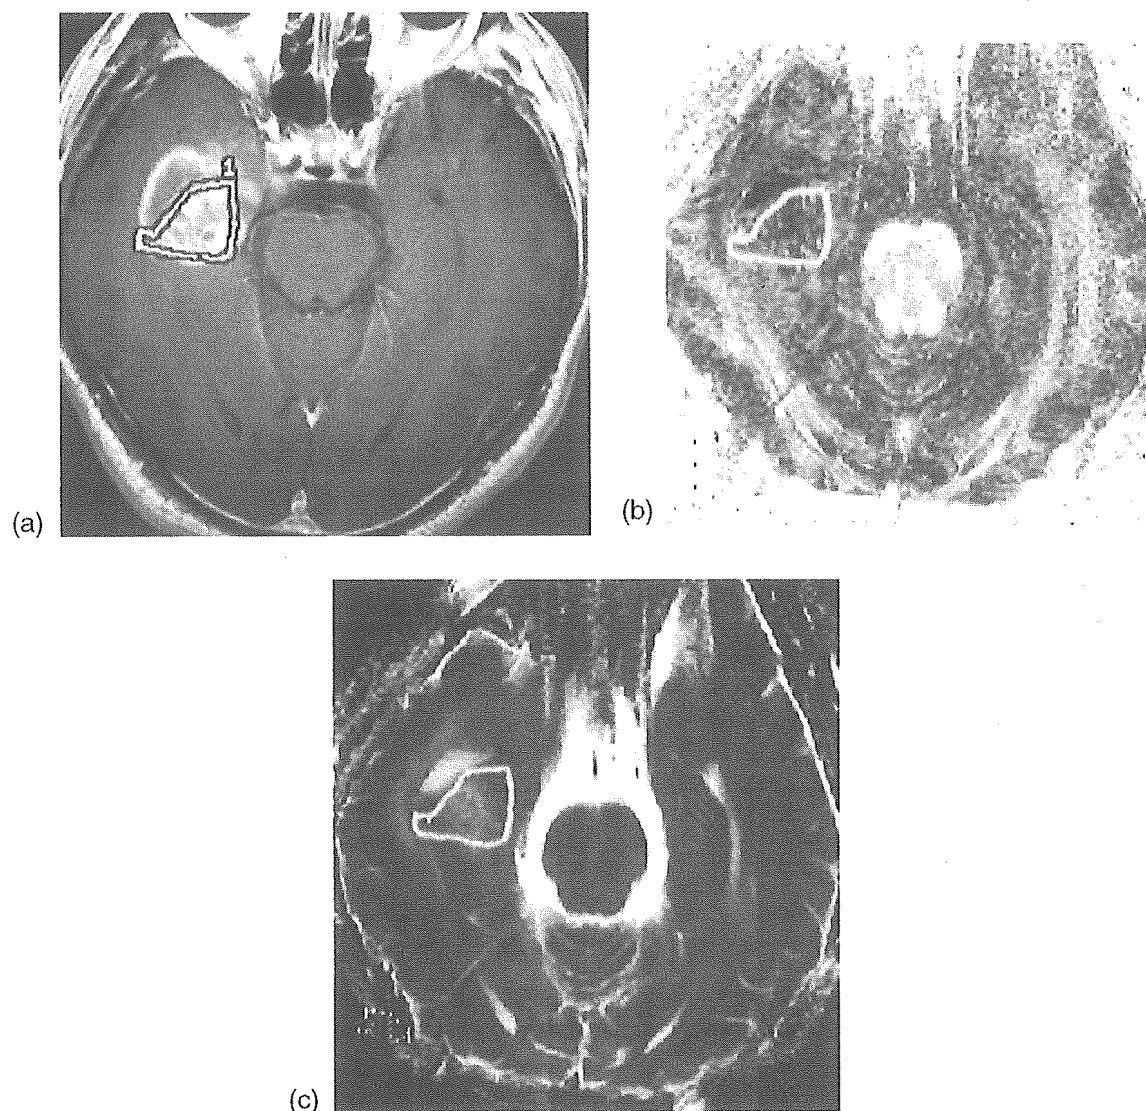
(a) T1-weighted magnetic resonance (MR) image with contrast medium showing the region of interest (ROI) in the solid portion of the lesion. (b) Fractional anisotropy map showing the outline of the ROI traced automatically. (c) Mean diffusivity map showing the outline of the ROI traced automatically.
